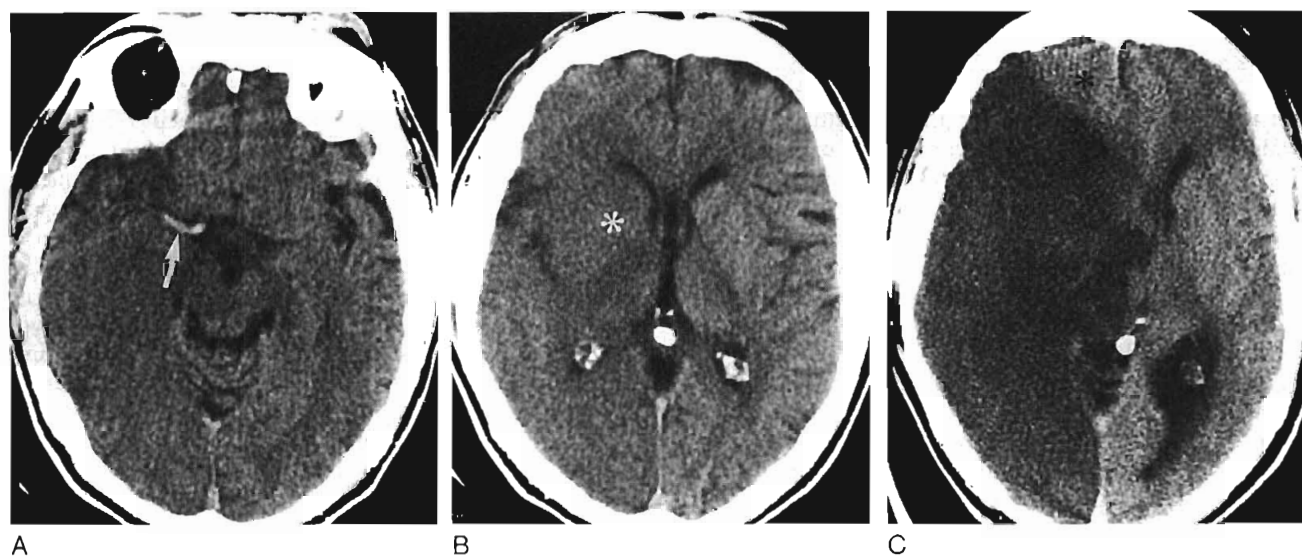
Acute infarct. Axial non-contrast-enhanced CT images obtained at the level of the temporal lobe (A) and through the level of the basal ganglia (B) demonstrate an area of low density involving the gray and white matter of the right hemisphere. There is loss of gray-white matter differentiation, especially noticeable in the region of the basal ganglia (asterisk, B). Compare the right and left sides. High density is identified within the right middle cerebral artery (arrow, A), representing clot. Axial non-contrast-enhanced CT scan obtained 48 hours later (C) demonstrates marked edema involving the territories of the right, middle, and posterior cerebral arteries. Note the sparing of the right anterior cerebral artery territory (asterisk, C).
